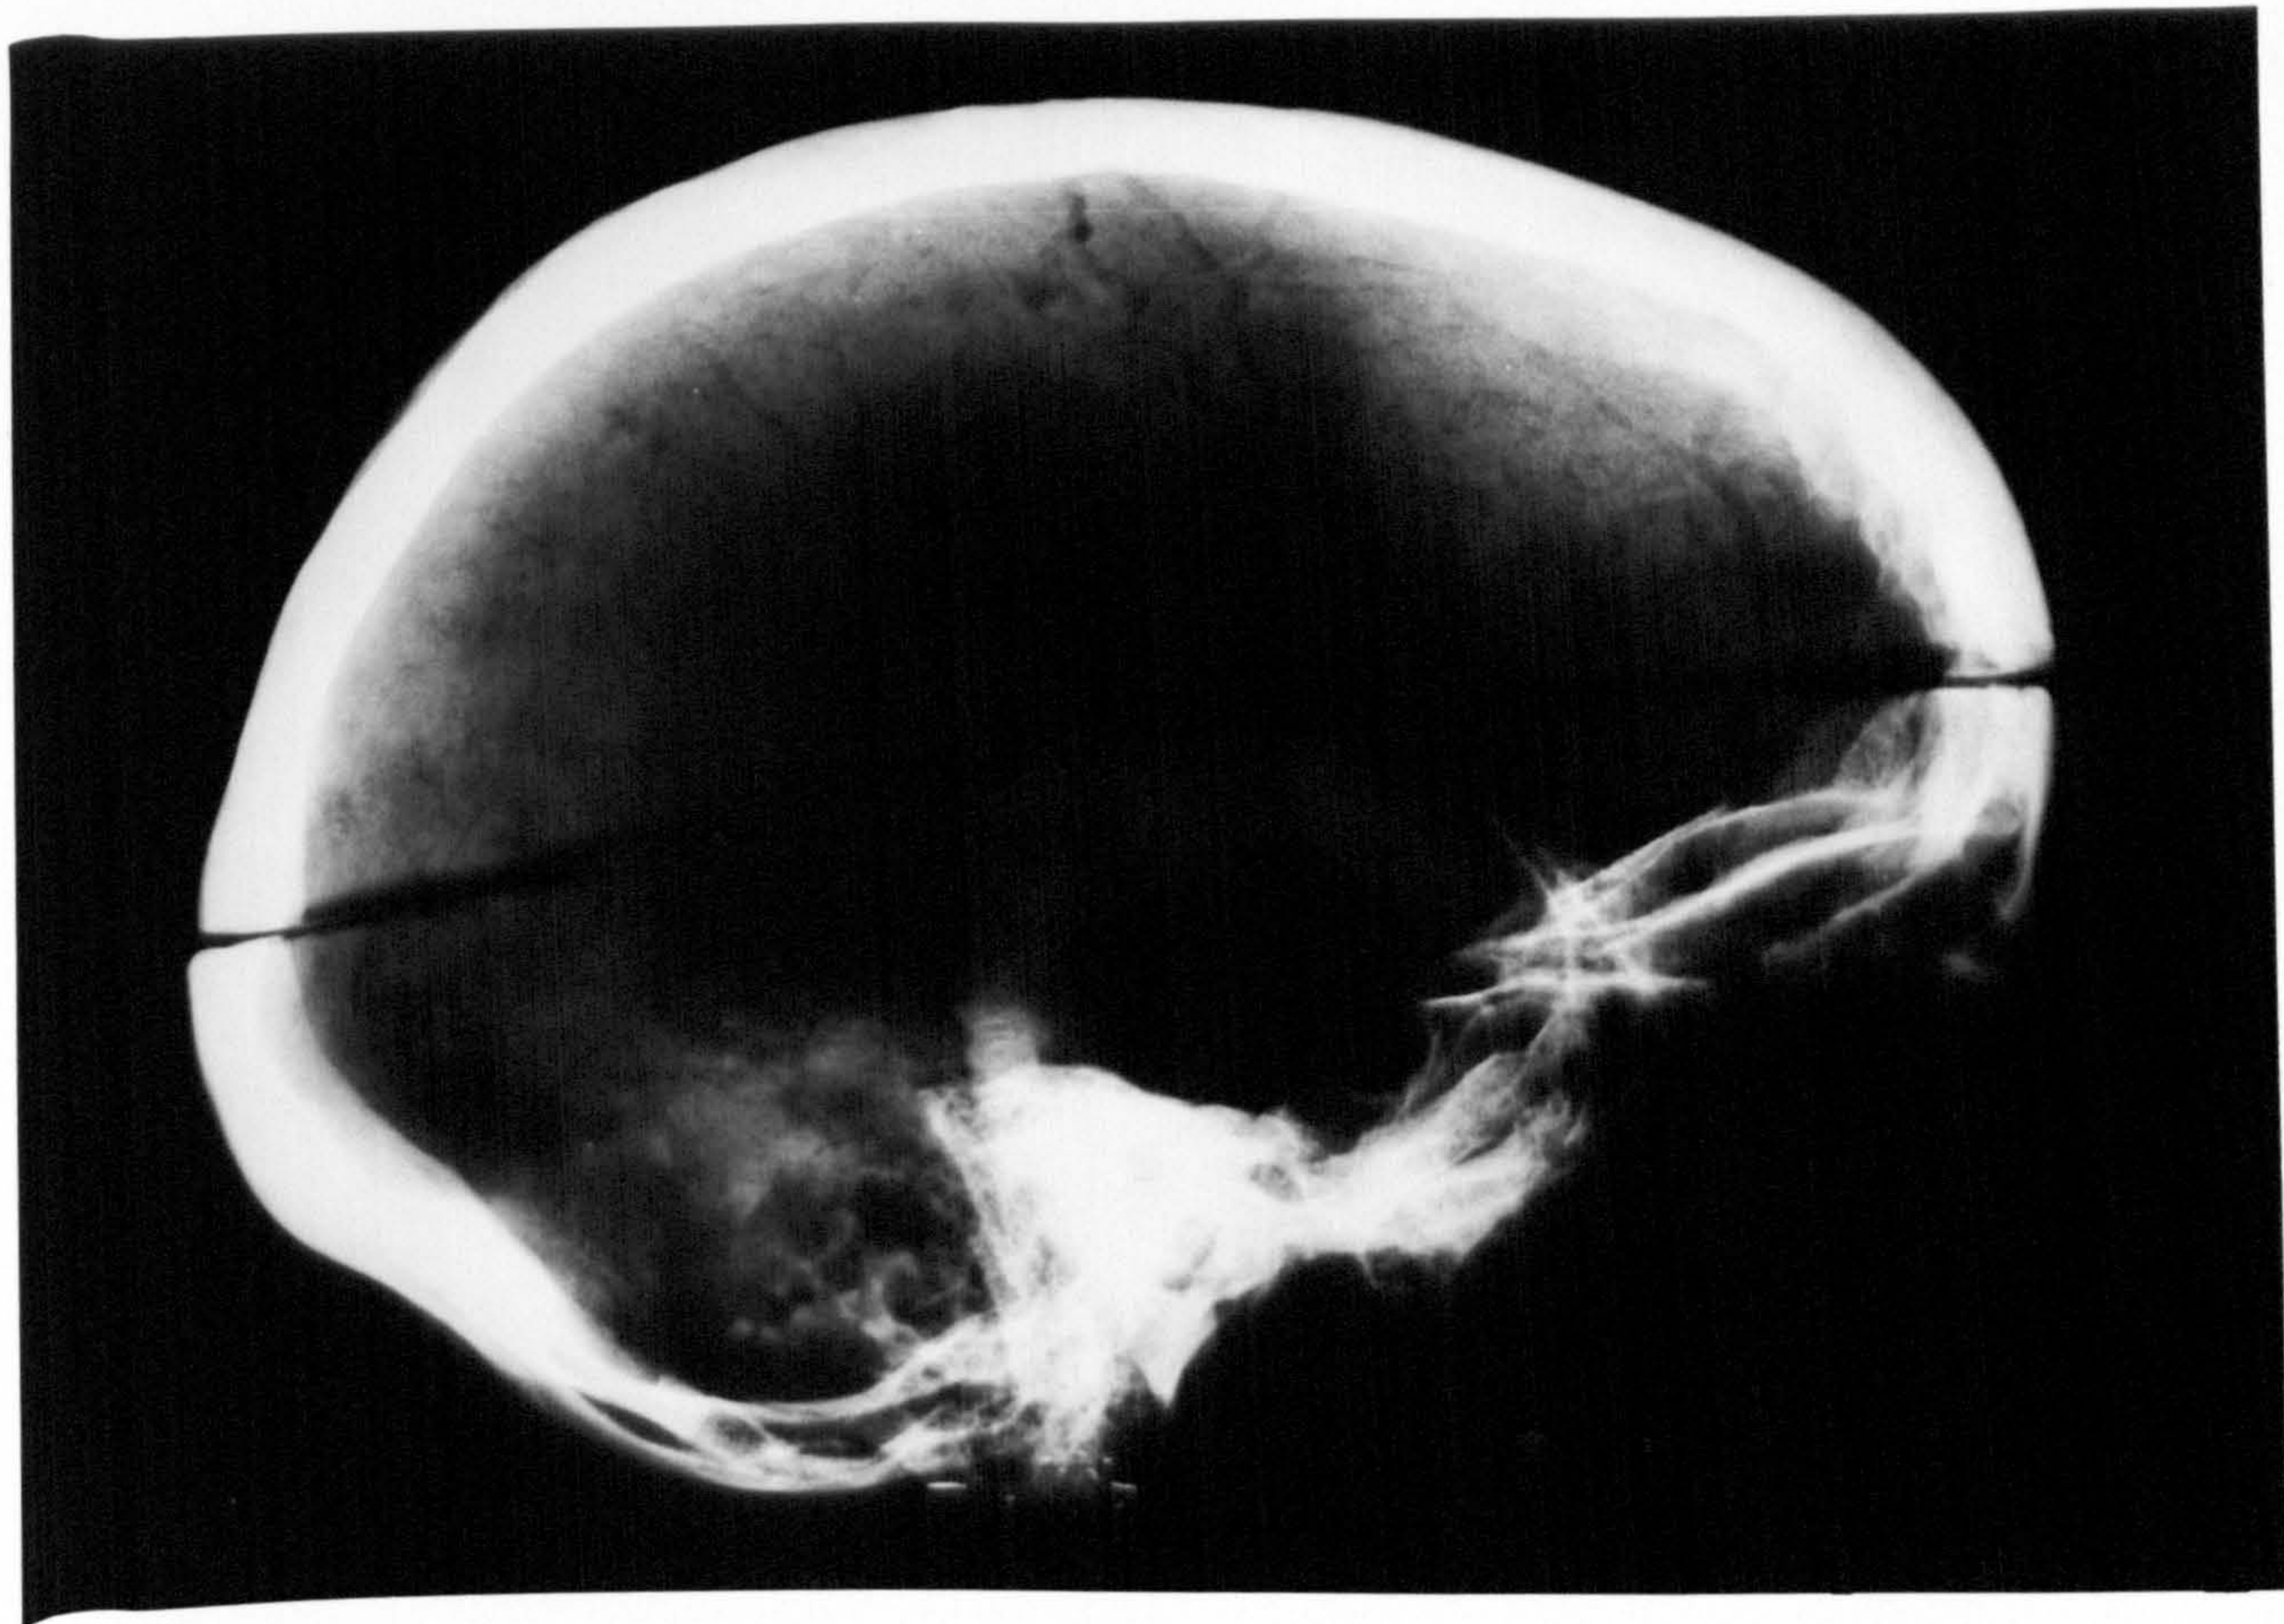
X-ray appearance and visual appearance of grade 3 HFI
